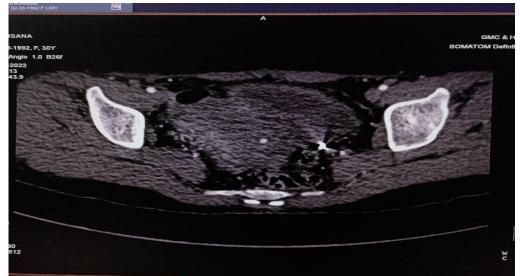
Axial CT angiography showing well defined contrast enhancing pseudo-aneurysm arising from left uterine artery. Previous aneurysmal clip seen in proximal left uterine artery
